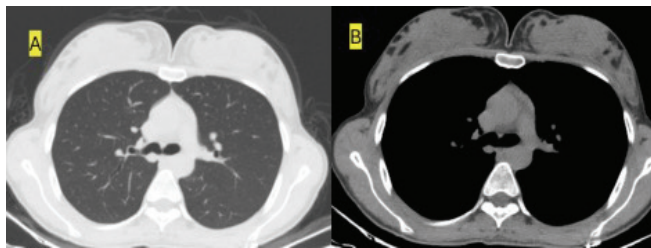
CT image of the lesion localized in the right main bronchus. A: Thoracic computed tomography parenchymal section image of the lesion in the right main bronchus localization, B: Mediastinal section image.
